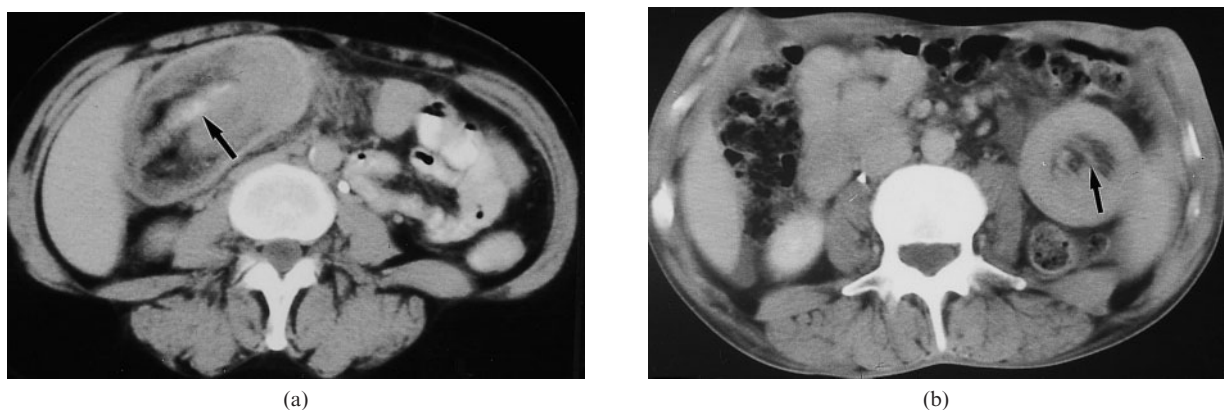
Lymphoma of the ileocaecal valve presenting as intussusception. A 56-year-old woman with abdominal pain of several weeks' duration. (a) CT image through the mid abdomen (parallel to the axis of the intussusception) shows an elongated mass lesion. A central sliver of contrast medium (arrow) represents the intussuscepted bowel loop, surrounded by mesenteric fat and the walls of the intussusciens. (b) Image 2 cm caudal to (a). A ring-shaped mass is now seen in the left midabdomen, with a thick soft tissue density representing opposing bowel walls. Mesenteric vessels course within the central low density mesenteric fat (arrow). Colocolic intussusception was found at surgery.
